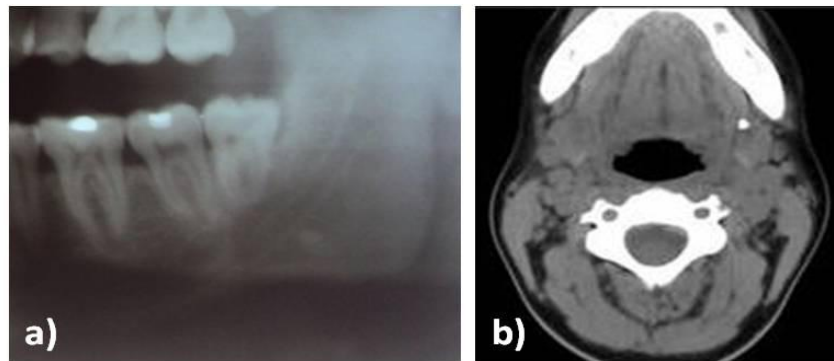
a) Cropped OPG showing well defined, roughly oval radiopaque structure below the inferior alveolar nerve canal distal to 38 b) CT scan showed a hyper dense area measuring approximately 8.7 X 6 mm, at the proximal part of the left submandibular duct.
